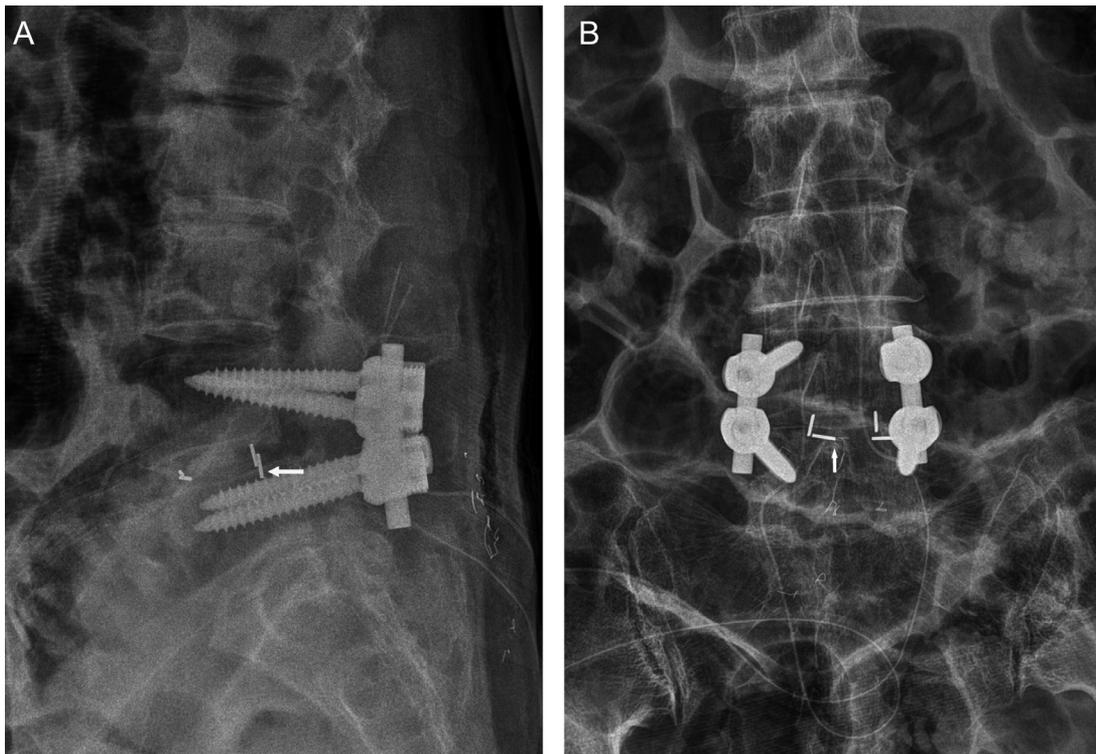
Endplate injury at immediate postoperative X-ray. We defined an endplate injury as the cage breaching into the cortical endplate on the immediate postoperative X-ray (A: Lateral view, B: anteriorposterior view).
